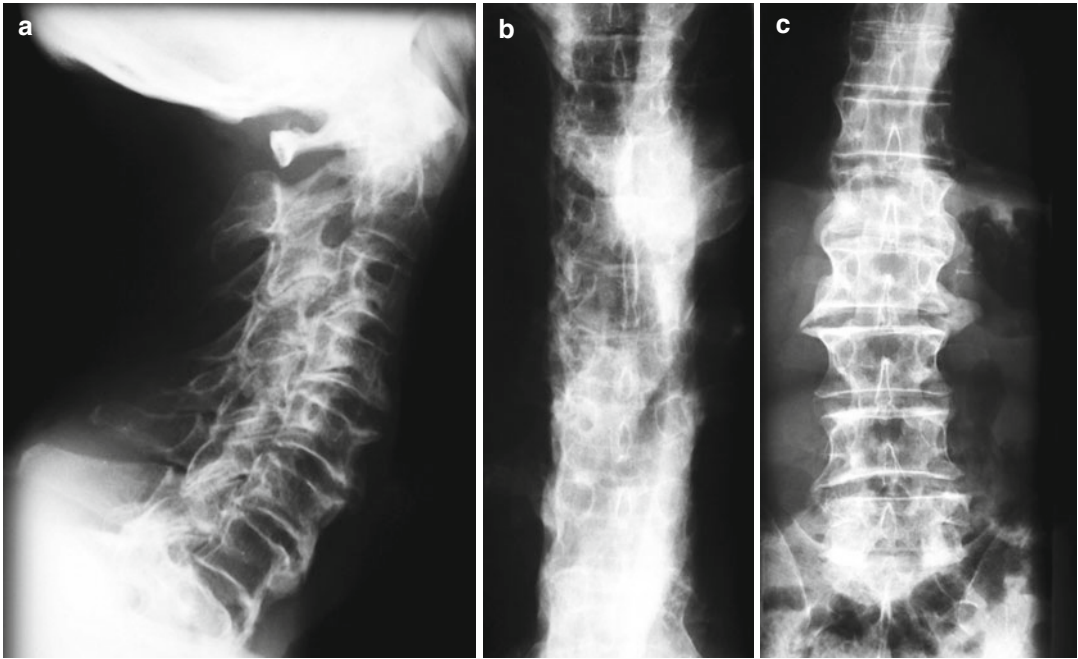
Radiography of C, Th and LS spine – massive flowing ossifications
